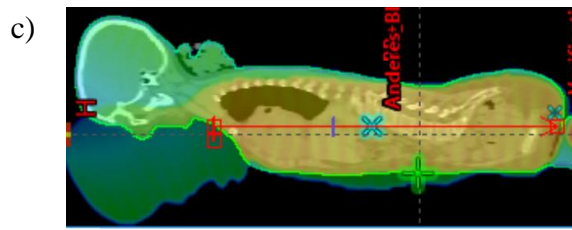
Dose distribution visualization in the head, torso, and legs, with corresponding dose profiles across the red line visible on the CT slice image. The prescribed dose for 1 fraction was $D_0 = 2$ Gy. For the head dose profile images, the total dose profile is the red line with maximal dose values, and individual fields dose profiles affecting the region are also displayed there.
